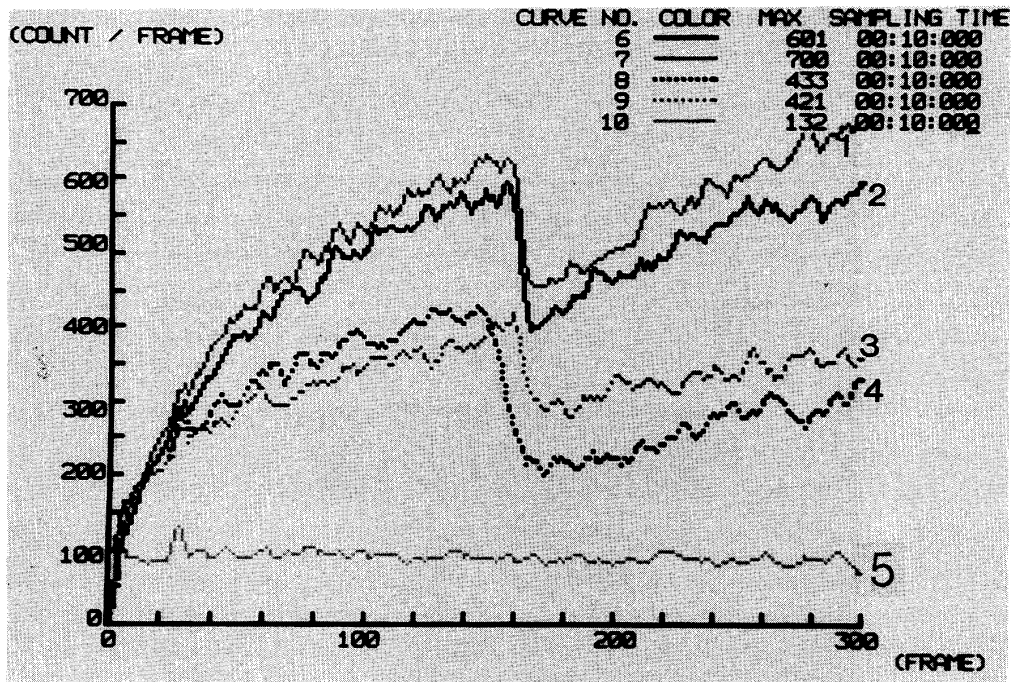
Time Activity Curves of Sequential Sialoscintigraphy
